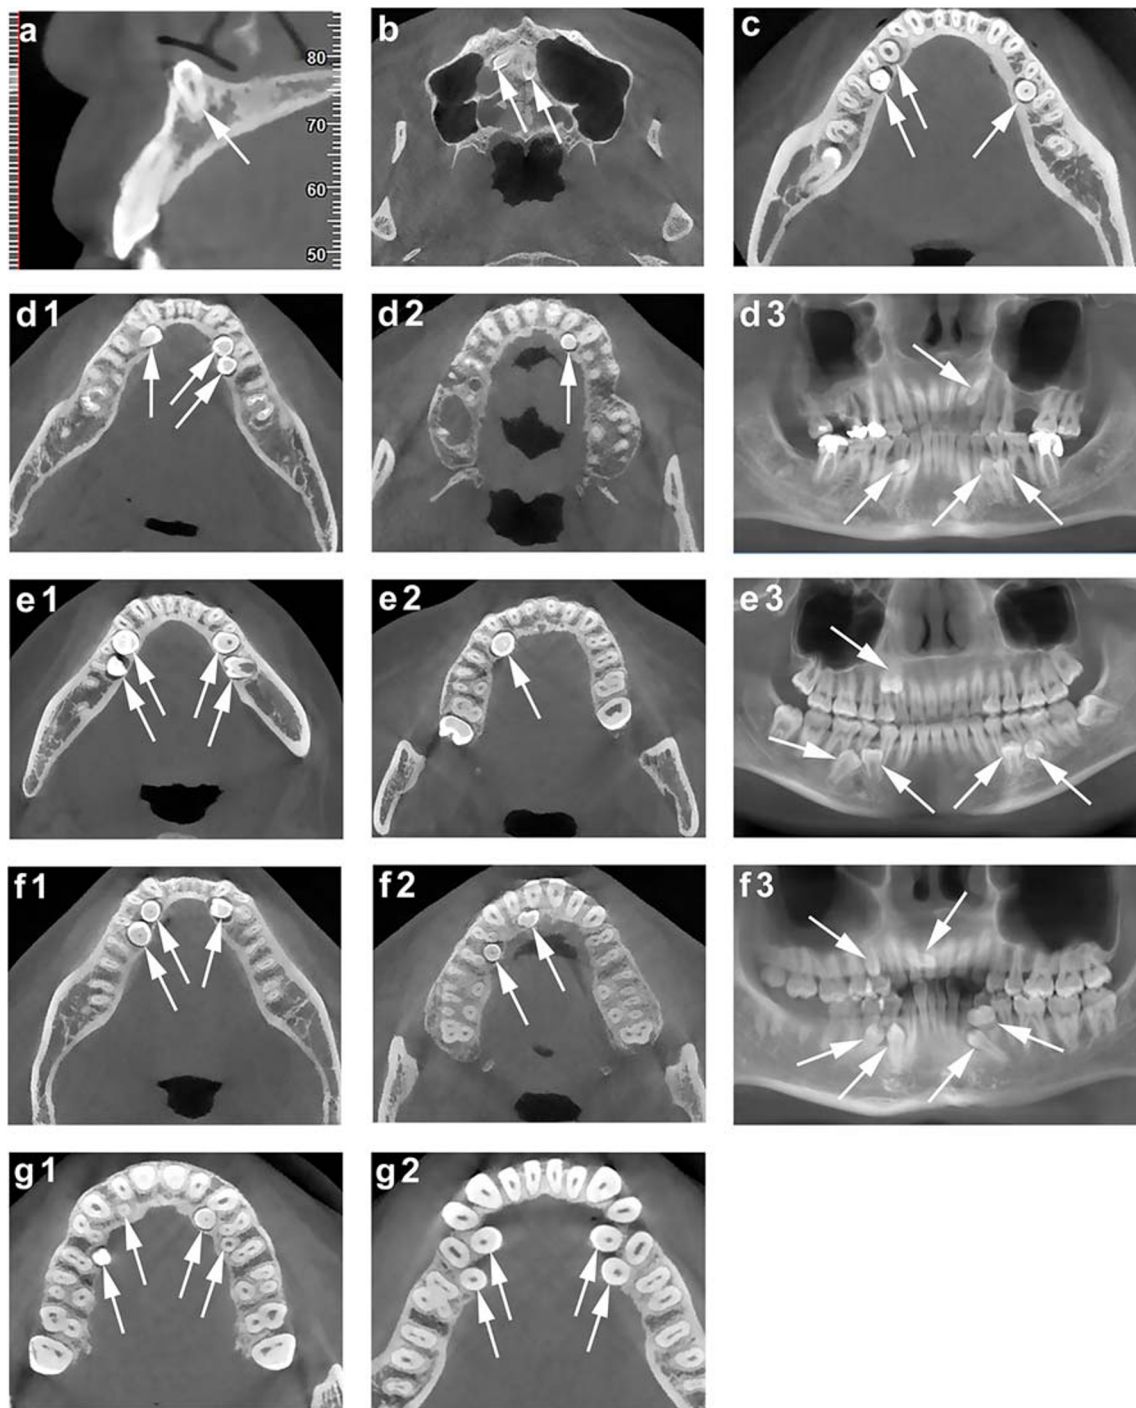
Representative CBCT images exhibiting diverse numbers of ST. (a) Single ST; (b) Two ST; (c) Three ST; (d1–d3) Four ST; (e1–e3) Five ST; (f1–f3) Six ST; (g1–g2) Eight ST. The white arrows point to the ST in the CBCT images
